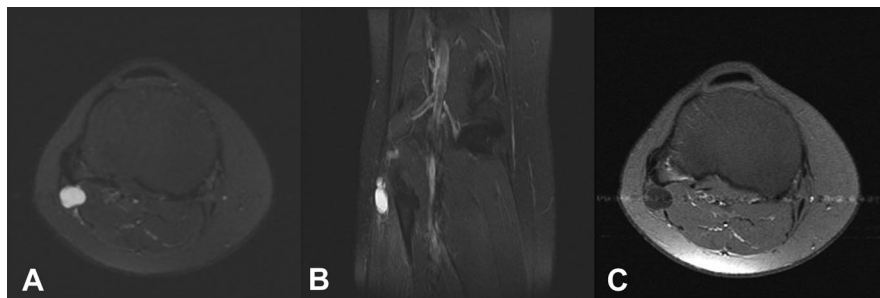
Right knee MRI: T2 fat saturation images; oblique axial (A) and coronal (B) showing a cystic mass in the lateral right knee. Oblique axial T1 post gadolinium (C) shows no enhancement of the mass.
